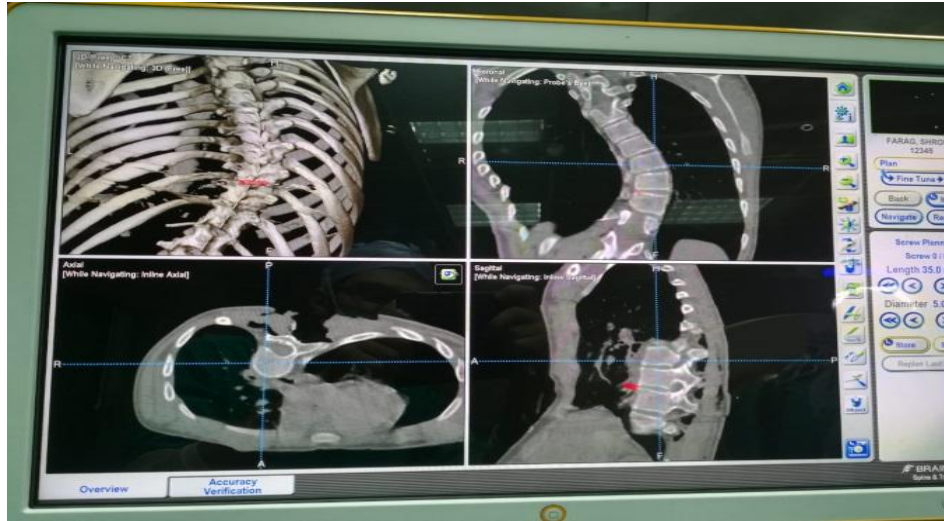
Figure from navigator intraoperative CT screen
